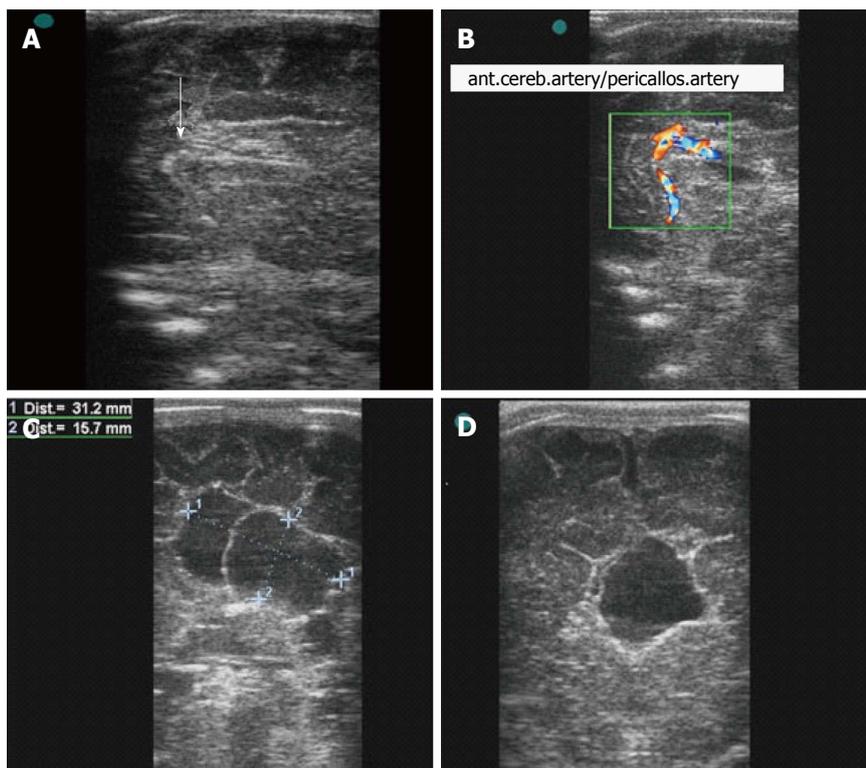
Transfontanellar ultrasonography. A: In the sagittal plane, showing the knee of the corpus callosum (with arrow); the spleen and posterior segment were not observed; B: In the sagittal plane, showing partial agenesis of the corpus callosum with the aid of color Doppler on the pericallosal artery; C: In the parasagittal plane, showing a cyst in the inter-hemispherical fissure; D: In the coronal plane, showing a cyst in the inter-hemispherical fissure and porencephaly.
